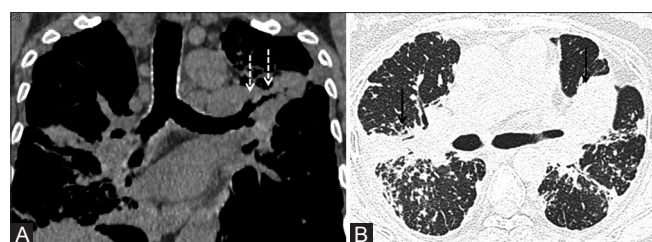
(A and B): Sarcoidosis: Parenchymal fibrotic changes. (A) Coronal reformatted CT image (mediastinal window) and (B) axial high resolution computed tomography (HRCT) image (lung window) in a patient with sarcoidosis shows bilateral confluent parahilar fibrotic masses extending to upper lobes (solid arrows). Note volume loss in left upper lobe with pulled-up left upper lobe bronchus (dashed arrows)
